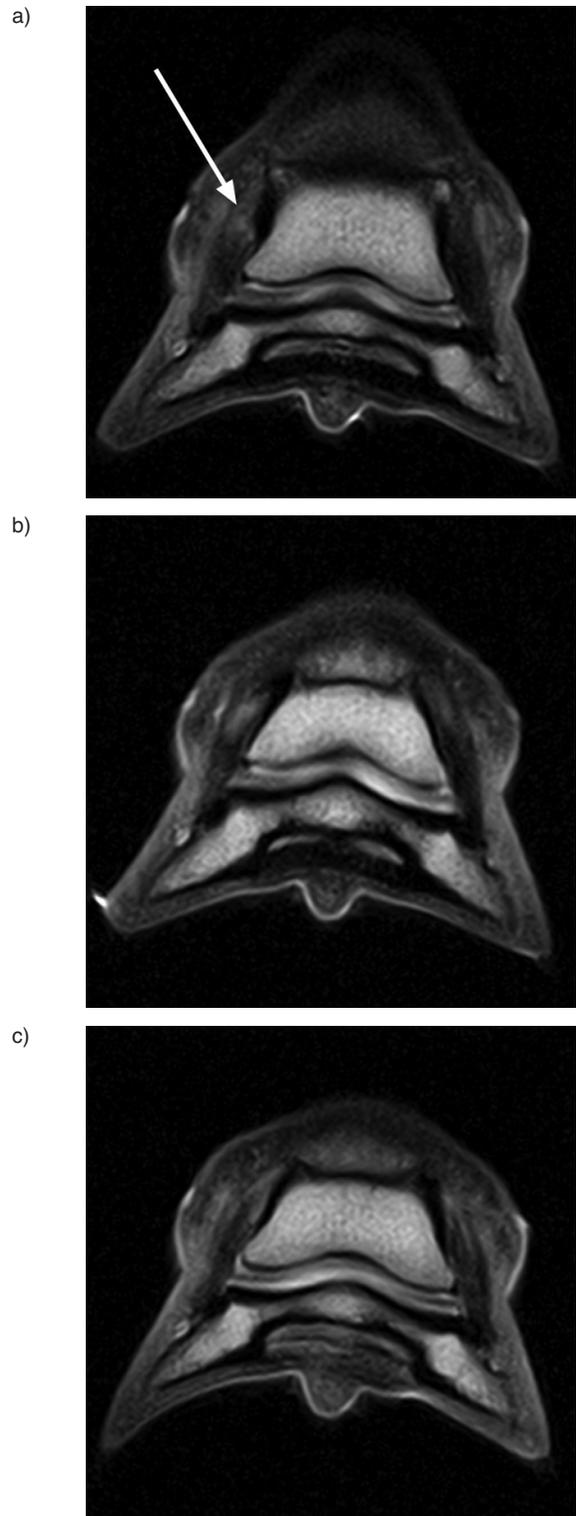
Effect of rotation on the signal intensity in the collateral ligaments of a foot with mediolateral hoof imbalance on T1-weighted images. Dorsal spin echo T1 weighted images of Foot 2 at the level of the collateral ligaments of the distal interphalangeal joint with 0° of rotation (a), 15° of external rotation (b) and 30° of internal rotation (c). Lateral is to the left. This foot presents mediolateral hoof imbalance with a higher lateral coronary band. A mild increase in signal intensity is present at the origin of the lateral collateral ligament on image a) (arrow). A more pronounced increase in signal intensity is present with external rotation (b). On image c), with internal rotation, both the lateral and medial collateral ligaments present a normal hypointense signal.
